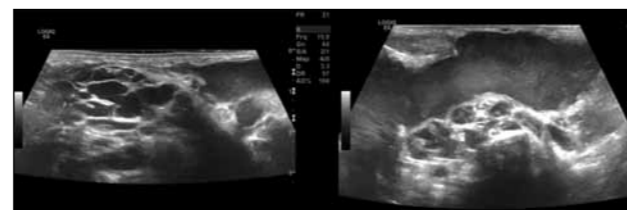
Multicystic LM in neck (of same patient as MRI in Figure 2).
